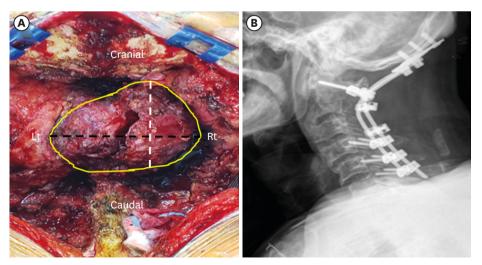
(A) Gross image of the exposed tumor. The tumor was found to be approximately 7.91 (black dotted line) × 5.24 cm (white dotted line) in size, to have an irregular margin (yellow line), to be pinkish, to be located at the C2-3 level and to involve the C2 lamina. (B) Postoperative cervical spine X-ray.
